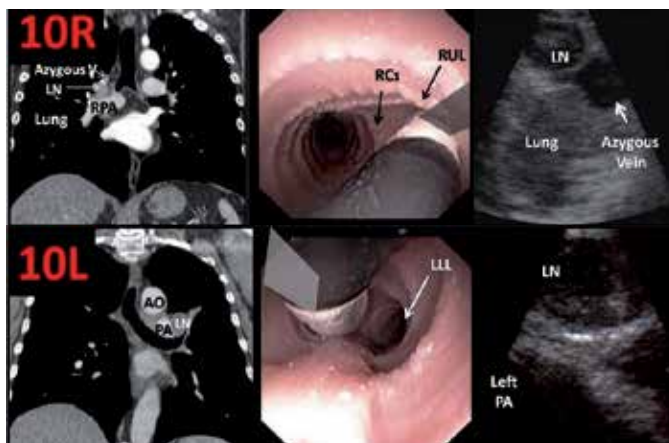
Station 10 lymph nodes: sagittal CT, endobronchial view and corresponding EBUS [106]. Courtesy of Septimiu Murgu, MD and Henri Colt, MD; Bronchoscopy International www.bronchoscopy.org
